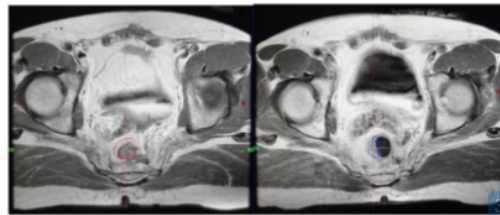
MRI imaging of pre (red circle) and post (blue circle) chemoradiation with carbogen inpatient with locally advanced rectal cancer.
